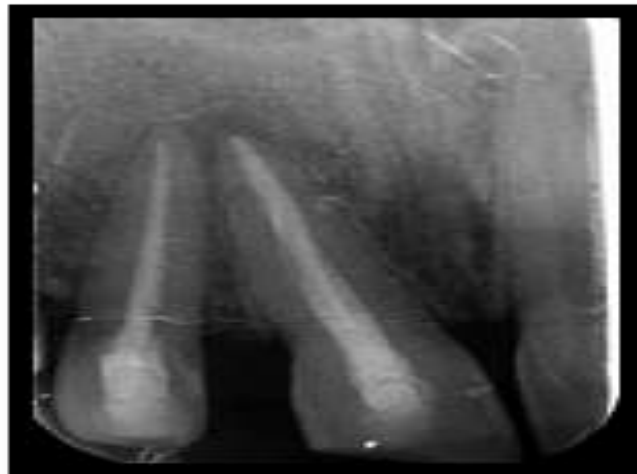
Follow up after 1yr showing healing of periapical area
